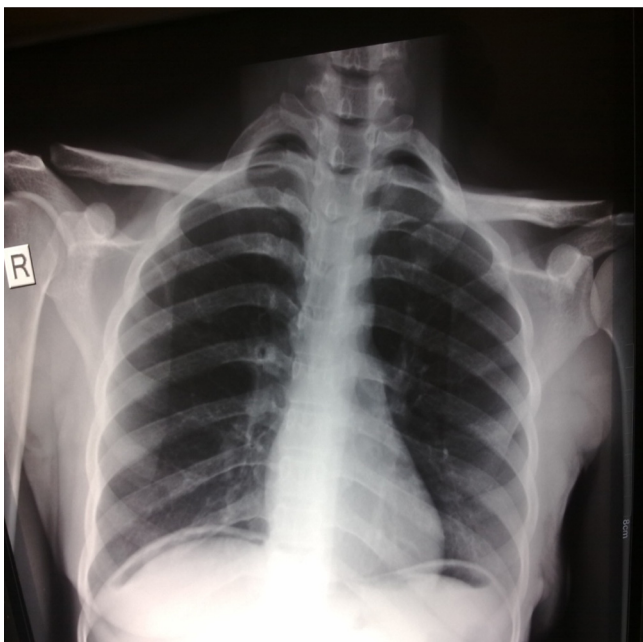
Chest radiograph showing pneumoperitoneum.
